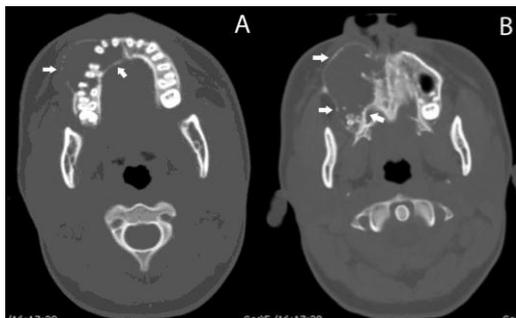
A. Axial CT Section showing hypo-attenuated image and, buccal and lingual distention of the cortical plates (arrows). B. Tumor mass causing the extra-oral swelling is evident.
